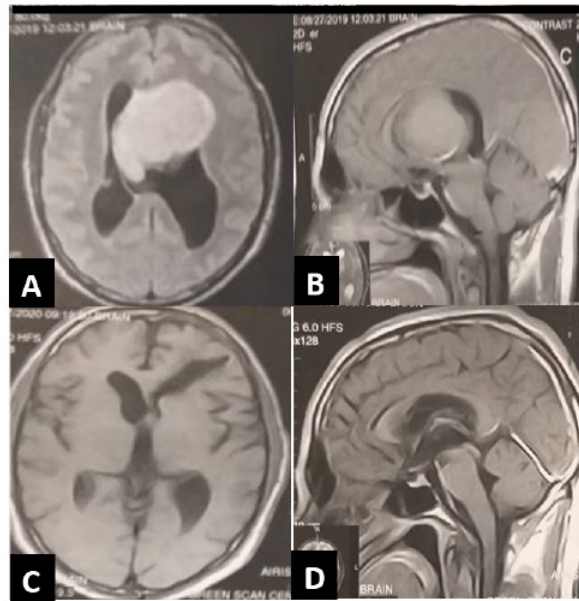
(A): Preoperative axial MRI with contrast: showing huge hyper intense intraventricular space occupying lesion and hydrocephalus, (B): Preoperative sagittal MRI with contrast, (C): Postoperative axial MRI with contrast showing gross total resection of the lesion and (D): Postoperative sagittal MRI with contrast showing gross total resection of the tumor.
